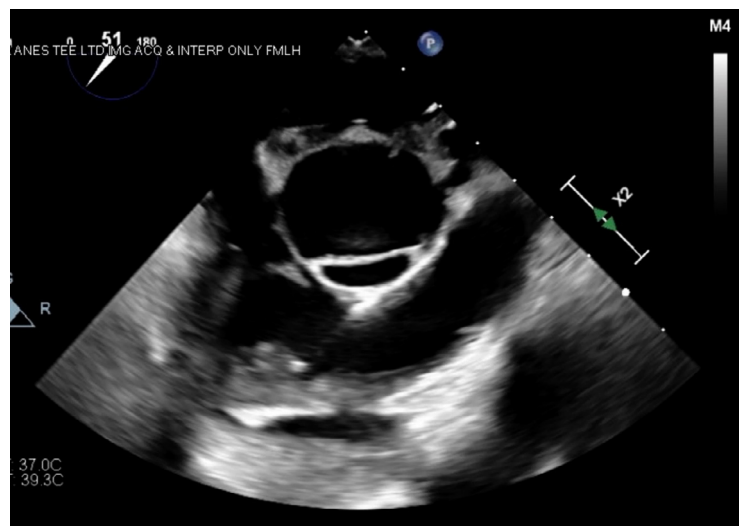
Midesophageal right ventricular inflow-outflow transesophageal echocardiography view during systole.
